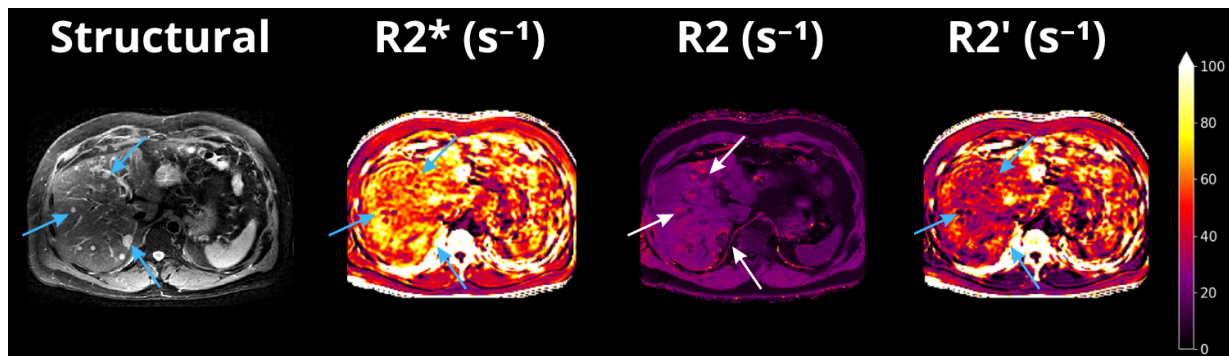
Patient relaxation maps acquired on a 3T MRI scanner. The left image shows a T2-weighted structural reference scan, while the middle and right images represent quantitative relaxation maps. Arrows indicate tumor tissue in the liver.
